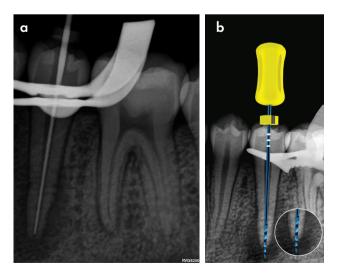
(a) Working length determination confirmed radiographically using a size 40 K-File; (b) Final canal preparation using a ProTaper Ultimate FXL manual instrument 2–3mm past the radiographic apex that equates to approximately an ISO 80 file size
